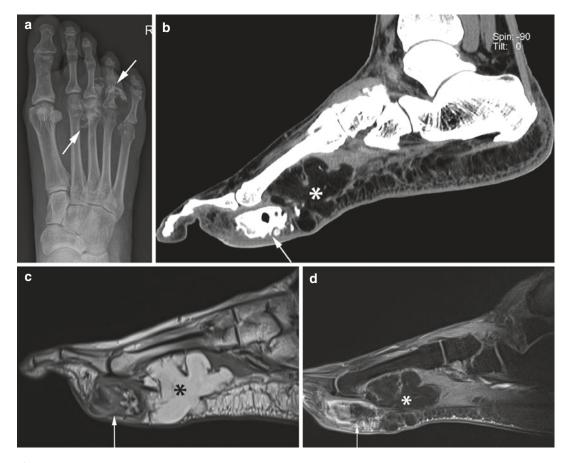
(a–d) Chondroid lipoma within the plantar aspect of the right foot. (a) Plain radiograph. (b) CT scan. (c) Sagittal SE T1-weighted MR image. (d) Sagittal FS SE T1-weighted MR image after gadolinium contrast administration. The lesion lies separate to the metatarsals
